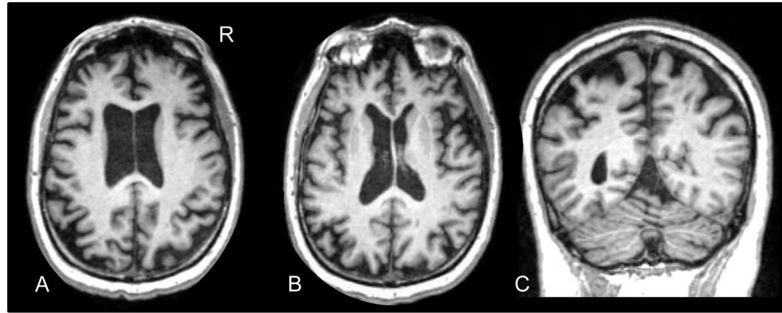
T1-weighted 3T MRI of Case 2, showing moderate bilateral parietal lobe and bi-frontal lobe atrophy, notably in the medial-frontal areas (A and B). Mild vermian (C) and caudate atrophy (B) was also noted.
